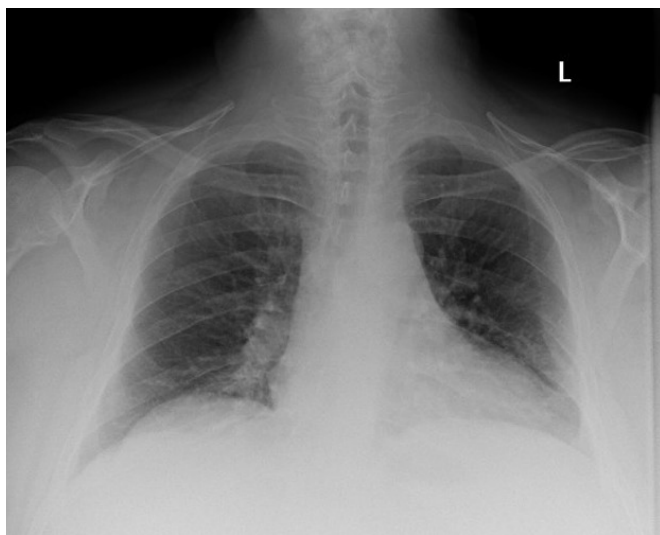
Chest radiograph from the initial presentation at the outside hospital taken 48 hours before re-presentation.
